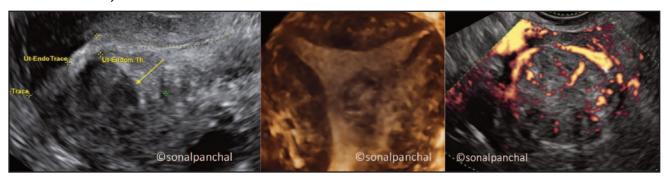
a,b. subendometrial fibroid on 2D ultrasound and 3D ultrasound. c. Fibroid showing peripheral vascularity on power doppler.
